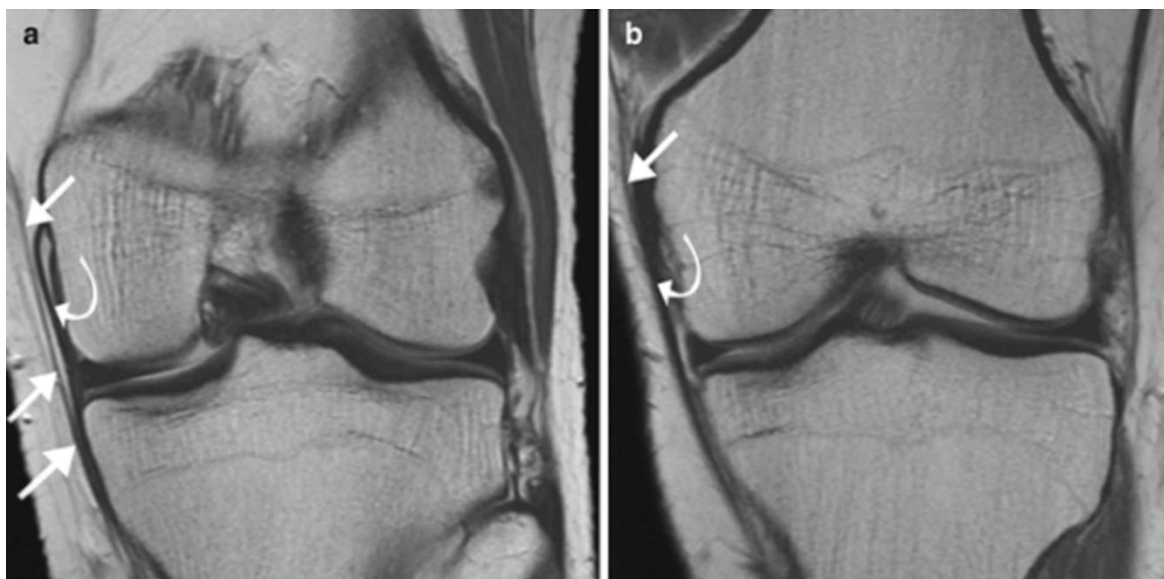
MRI coronal images showing MCL. (a) Deep fascia that is seen on MR images as a thin low-intensity structure (*arrows*) separated by a variable amount of fat from the superficial layer of medial collateral ligament known also as the vertical part of the ligament (*curved arrow*). (b) The deep fascia (*arrow*) joins the medial collateral ligament (*curved arrow in b*).
